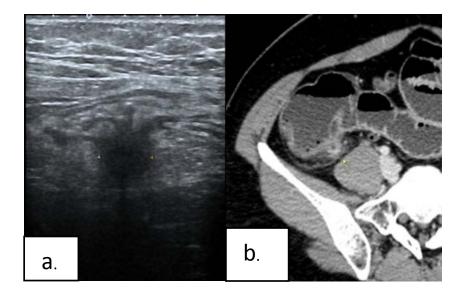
(a.) Ultrasound reveals a round hypoechoic structure (calipers) protruding from cecal wall with peridiverticular fat thickening. (b.) Corresponding contrast enhanced CT image shows thickening and enhancement of diverticular wall (arrow) with adjacent fat stranding, indicating acute diverticulitis.
